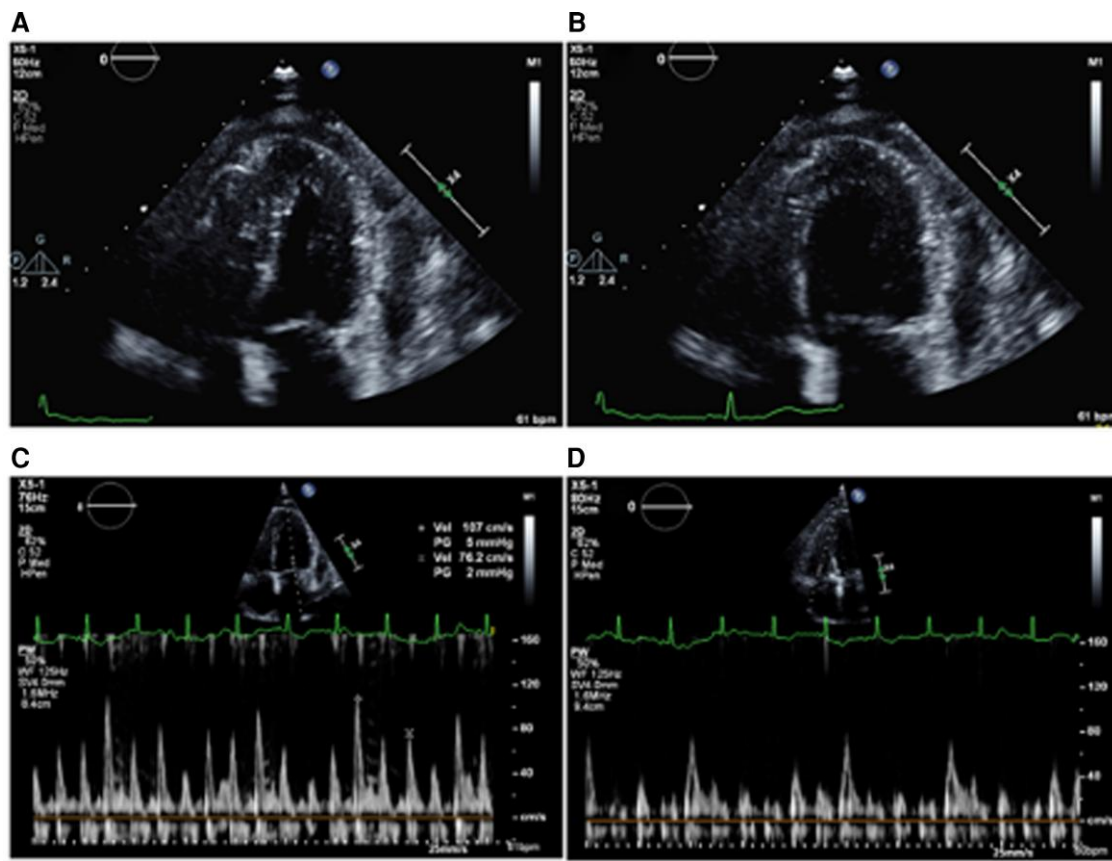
Transthoracic echocardiogram from the apical four-chamber view revealed respirophasic septal motion, seen at end-diastolic (A) inspiration and (B) expiration, and altered inflow velocities at the (C) mitral valve and (D) tricuspid valve.
